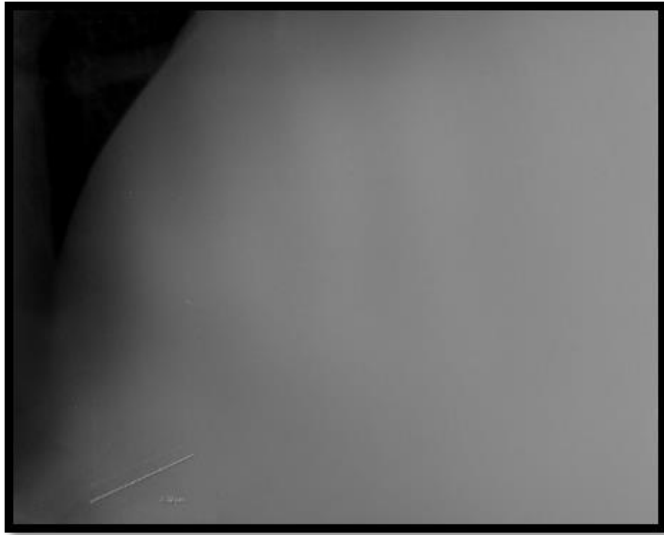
Radiograph showing metallic wire in reticulum
